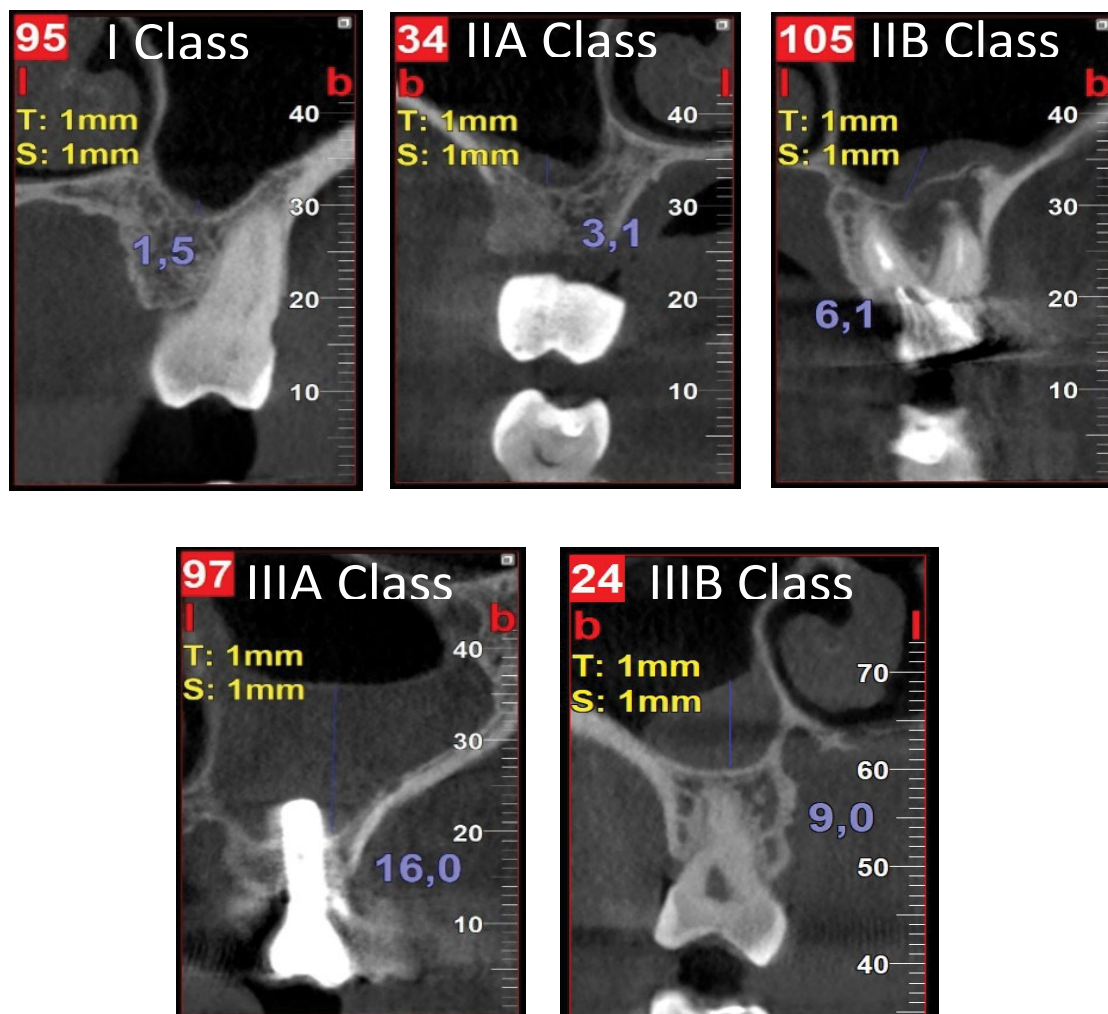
CBCT sections of maxillary sinus examples according to DiGirolamo classification.
